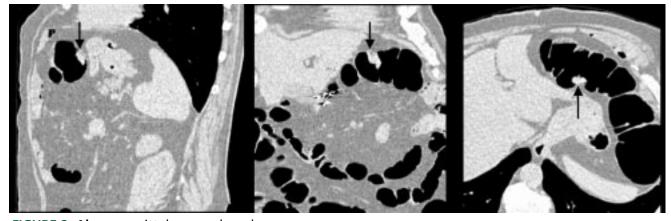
Above, sagittal, coronal, and axial multiplanar reformatted images from a CT colonography examination. Arrows point to a polypoid mass within the colon. Right, a virtual colonoscopy internal projected image of the lumen of the colon again demonstrates this polypoid mass.
